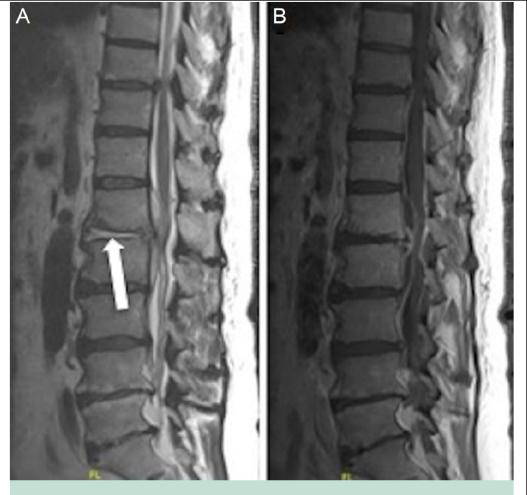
Discitis with associated ventral epidural abscess. Lumbosacral magnetic resonance image of a patient with diabetes mellitus who presented with acute on chronic low back pain, fevers, and weight loss. Sagittal T2 fluid-attenuated inversion recovery (FLAIR) imaging (A) and T1 postcontrast imaging (B) show high T2 signal within the L1-L2 intervertebral disc (arrow) and an associated ventral epidural fluid collection with peripheral enhancement. Blood cultures grew methicillin-sensitive *Staphylococcus aureus*.
